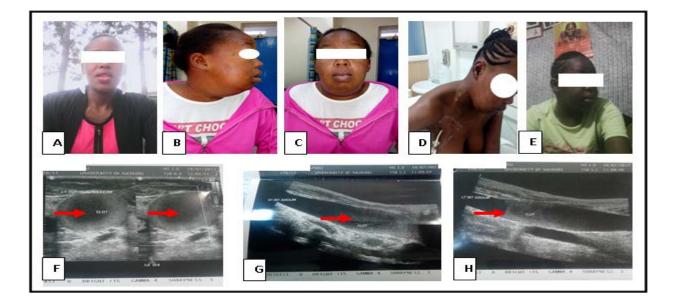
A - B.N face before thrombosis, B and C, B.N face at presentation, D –B.N face at 3 weeks before removal of the tunneled right internal jugular vein catheter, E- B. N face after removal of the catheter., F-H doppler ultrasound of the subclavian and jugular veins showing thrombi (red arrows).
